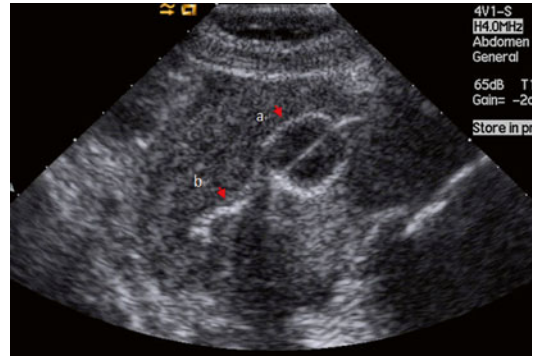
Percutaneous microwave ablation (MWA) in a 29-year-old woman with two type 3 fibroids with the sizes of 3.4×3.1 cm and 4.2×4.8 cm who was nulliparous. Because the fibroids are in contact with the endometrium, some defensive measures were taken to protect the endometrium. A 5 F double-lumen balloon urinary catheter was placed into the cavity. The balloon was filled with 1.5 ml of saline solution (*arrow a*). Then, 1 ml sterile ultrasound gel was slowly injected through the urethral catheter to mark the endometrium (*arrow b*). On the same section of ultrasound, the fibroids cannot be shown
